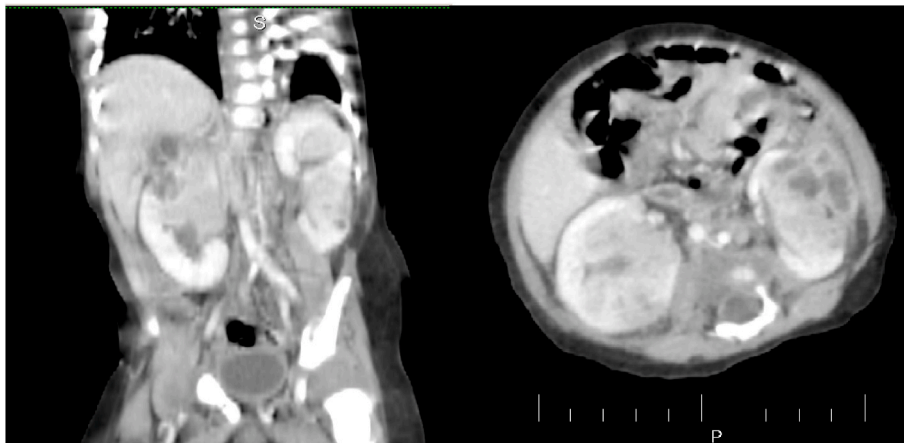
Contrast enhanced CT abdomen showed bilateral renal masses.
